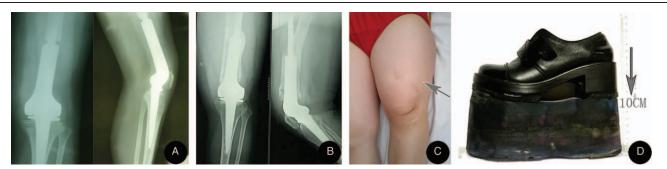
Radiograph (A) at the 2-year follow-up (in 1993) showing a replacement of the custom-made endoprosthesis of the knee joint with no sign of tumor recurrence or periprosthetic fracture. An anteroposterior standing radiograph (B) of the lower left limb showing fracturing of the proximal femoral stem, and the prosthesis stem on the femur side had passed through the femur toward the front. Preoperative photo (C) showing swelling and deformity of the left thigh (gray arrow). The patient's specially designed shoes (D), approximately 10 cm tall.
